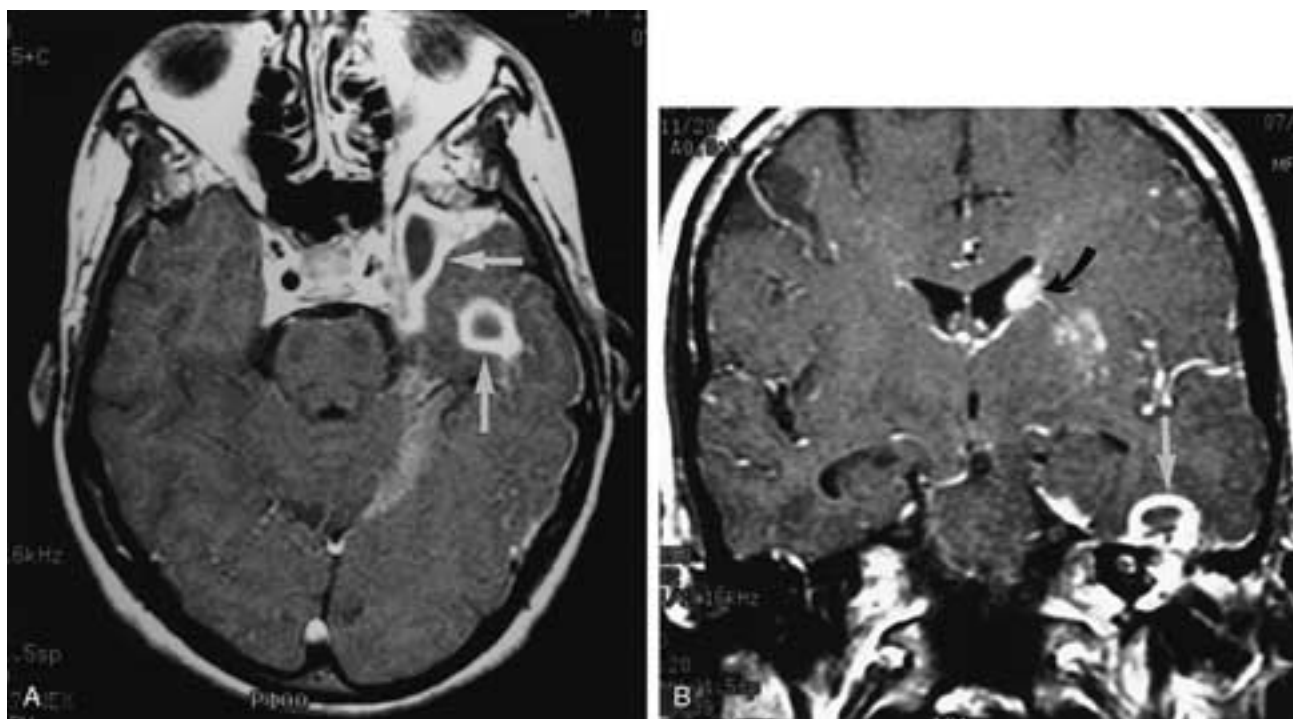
A and B, Otomastoiditis with epidural abscesses. T1-weighted, contrast-enhanced images show epidural abscesses (*arrows*). There was associated meningitis with involvement of the lenticulostriate arteries and the recurrent artery of Heubner, producing infarction in the basal ganglia and head of the caudate (*arrow*).
